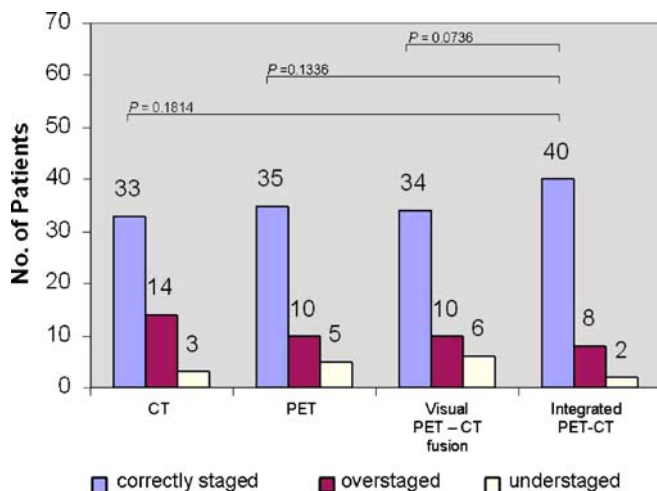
Accuracy of nodal (N) status for integrated PET-CT compared with CT, PET and visually correlated PET-CT
